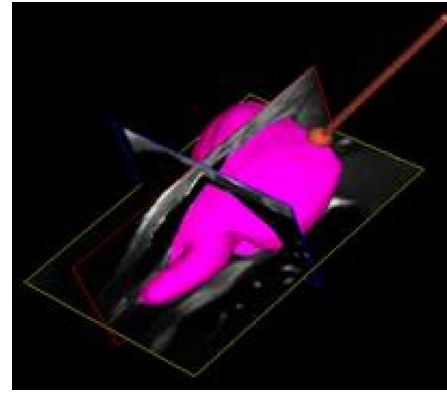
In this figure, the haptic model is mapped to the patient dataset (US images) through US/MR image registration.
